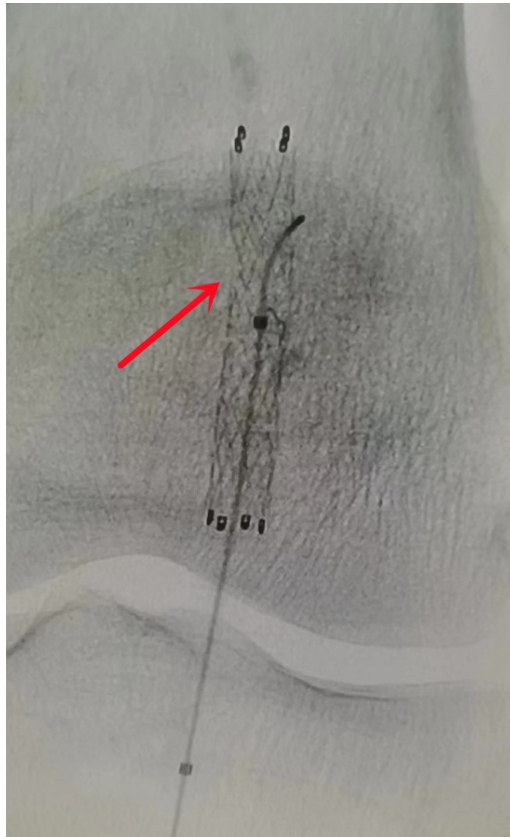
CTA of lower limb artery showed that after stenting of left popliteal artery, the stent was partially damaged
